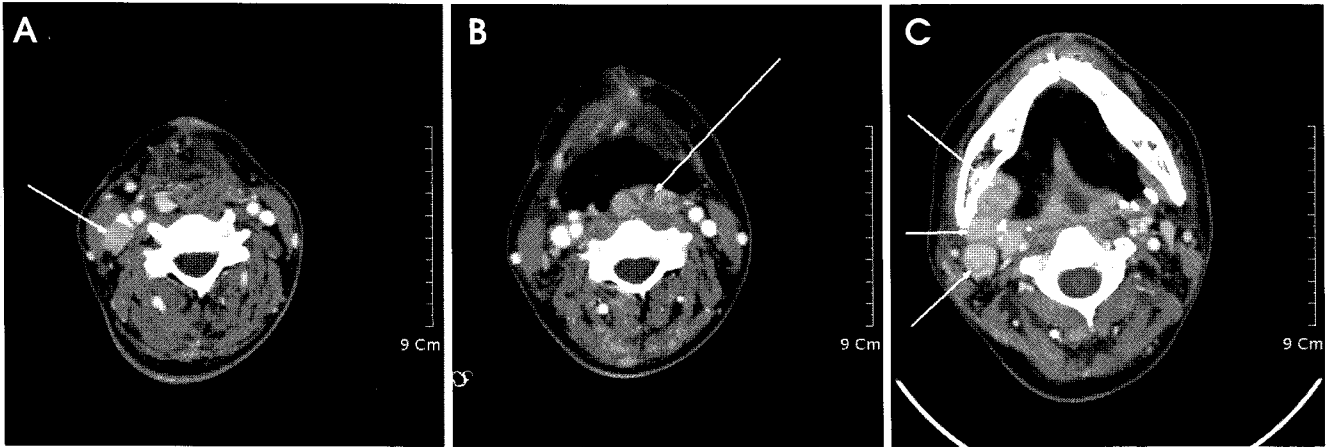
Enhanced CT images, two months after operation. (A) Lymph node enlargement is seen on the level III of the right neck. (B) An enhancing soft tissue lesion, indicating a recurrent mass, is noted at the pharyngeal wall adjacent to lower part of the posterior margin of operation site. It is extended inferiorly along the esophagus. (C) Multiple enlarged lymph nodes are seen on the level I and II of the right neck.
